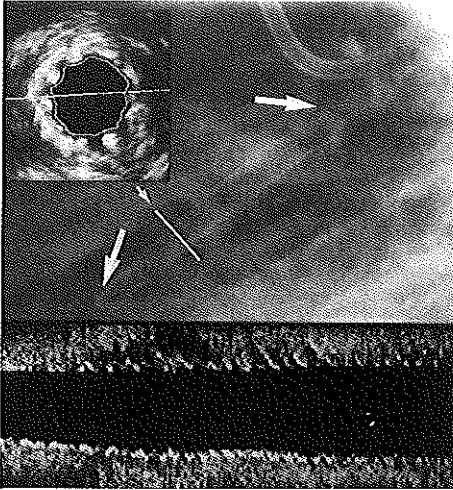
Wallstent after implantation in left anterior descending coronary artery. *Arrowheads* indicate proximal and distal ends of stent on radiographic image (*upper panel*). Location of 2D ICUS image (*insert*) is indicated by *small arrowhead*. Cross-sectional image is derived from 3D analysis system, performing semiautomated detection of blood pool on basis of application of pattern recognition algorithm. Longitudinal view (*lower panel*) is reconstructed, showing smooth tapering of luminal dimensions from proximal (*right*) to distal (*left*). Besides 3D, conventional 2D analysis was performed in this study on basis of review of videotape and manual contour tracing.
